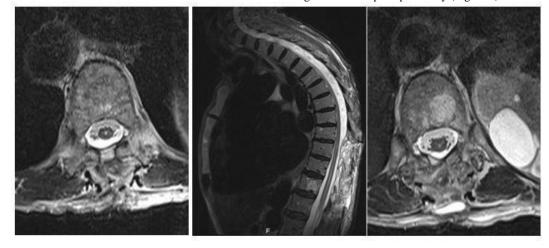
(A, B, C): Thoracic MRI; laminectomy T9-T12 with good decompression of the canal without medullar compression and no myelopathy.
